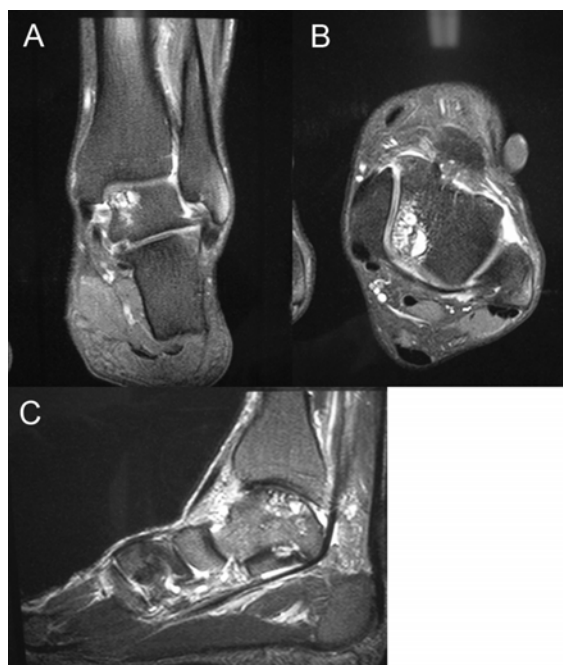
A-C, Preoperative MRI of the left talus
